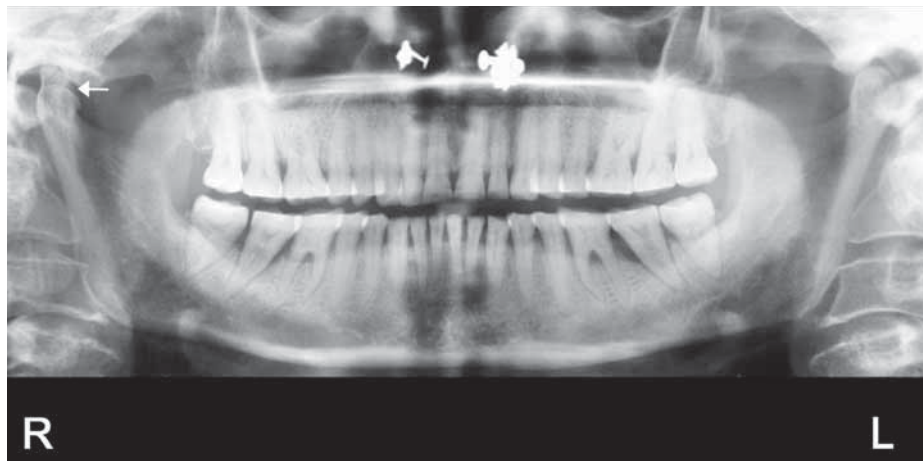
Case 1: Panoramic radiograph showing a bifid right mandibular condyle (see arrow).
